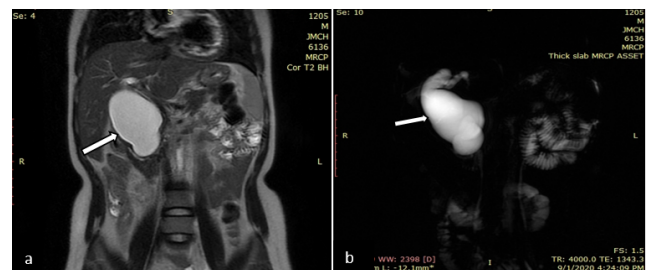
T2-weighted coronal; a: and thick slab MRCP; b: Reveals dilated CBD all throughout its course (thick white arrow), consistent with type IA Choledochal cyst.
